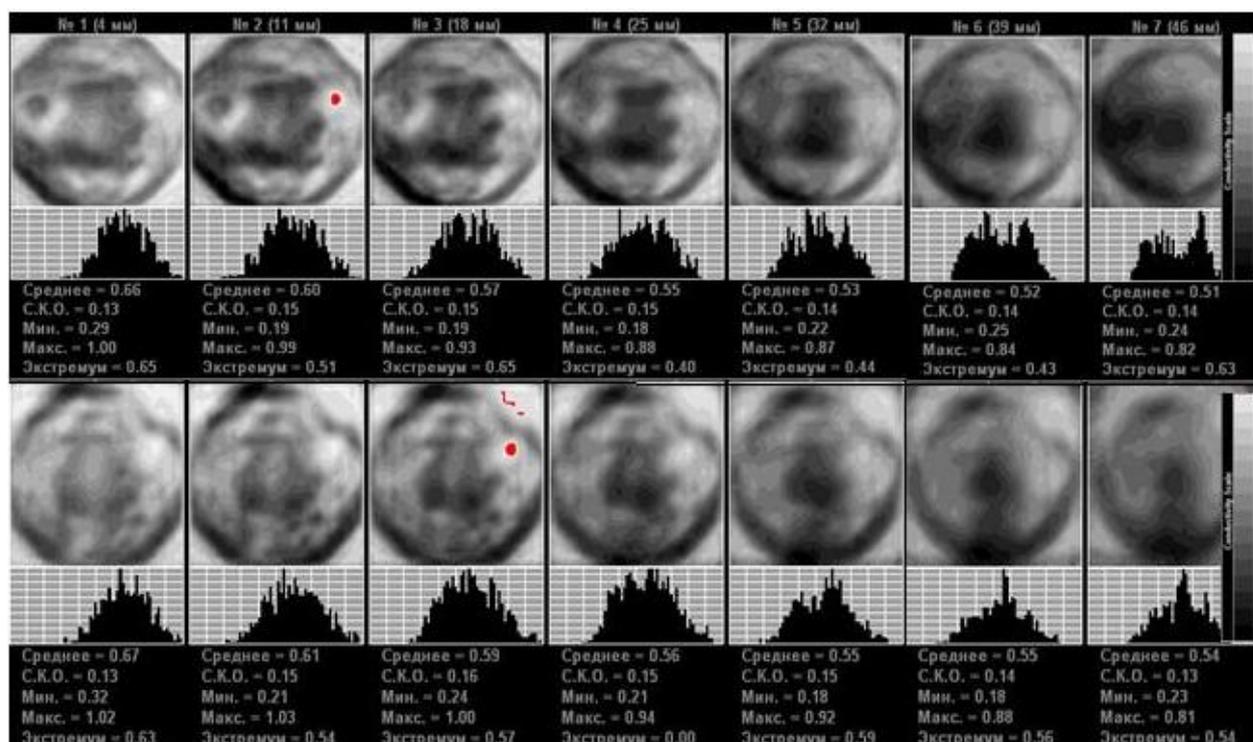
EIM. Outer segment. Amorphous type of mammary gland structure. In the outer segment of the left mammary gland (upper row), at 3 o'clock position there is observed an an-impedance area, which is highlighted with red in the second scan plane, 10 mm in size. The same area is visualized in the upper segment of the gland (second row) in the third scan plane, corresponding to the location of the lesion. ULTRASOUND: In the outer segment of the left gland there is an inhomogeneous lesion with blurred contour and with a hyper-echoic inclusion in the center with active blood circulation, its size is 1.7x0.9 cm. In the left axillary area there is a "set" of lymph nodes with hyper-echoic inclusions in the center.
